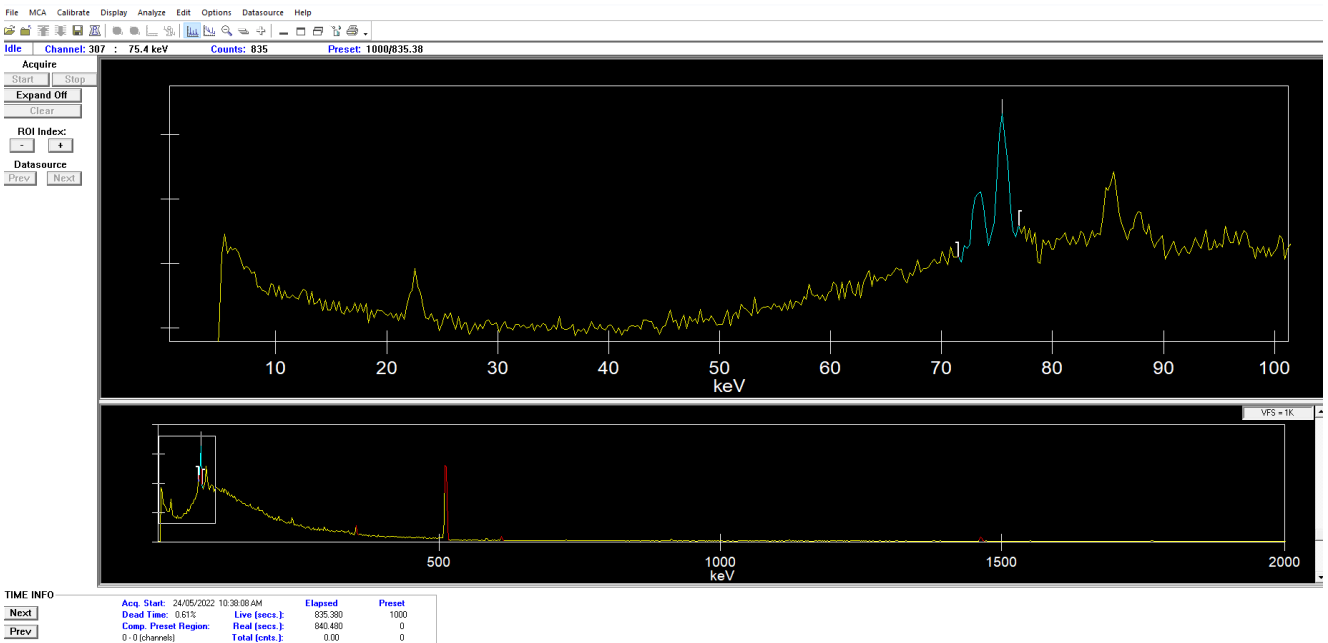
Close up view of the background file low energy region (below 100keV), showing the characteristic X-rays peaks at 73.2, 75.4, 85.5 and 87.7 keV due to the photoelectric effect of lead shielding.
